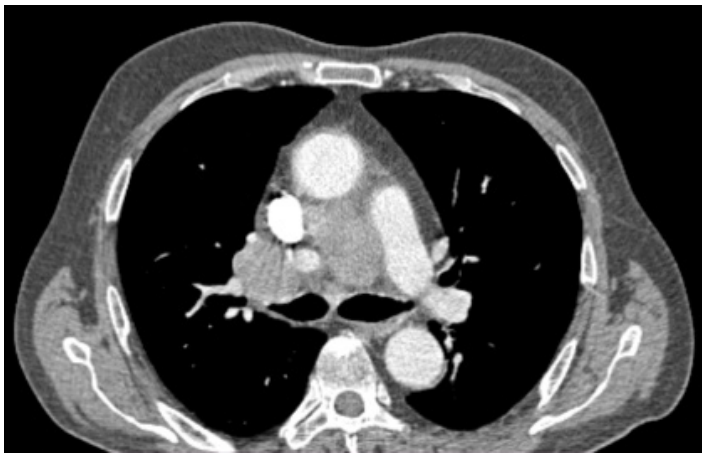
Contrast-enhanced thorax CT examination dated June 2018 revealed mediastinal multiple lymphadenopathies (white arrow-head) in the patient whose previous thorax CT examinations were normal
